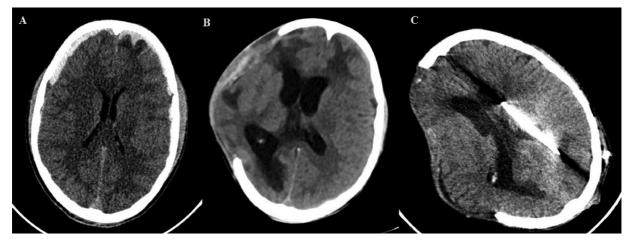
Post decompressive craniectomy hydrocephalus. Noncontrast CT head showing (A) a bilateral frontotemporal hemorrhagic contusion with bilateral frontoparietal acute SDH with a thickness of 6.4 mm on right and 4.5 mm on left with a midline shift of 3.8 mm. (B) Postcraniectomy with features of hydrocephalus managed by CSF diversion (C).
